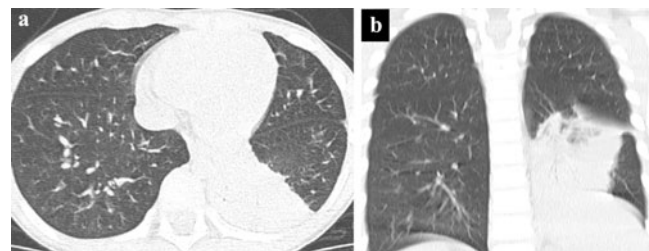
A 5-year-old boy with laboratory-confirmed S-OIV infection presented to the emergency department with fever, shortness of breath, and cough. a, b Axial and coronal images from unenhanced CT show consolidation with volume loss in the lateral basal and posterior basal segments of the left lower lobe and elevation of the left diaphragm. The consolidation with volume loss was interpreted as atelectasis
